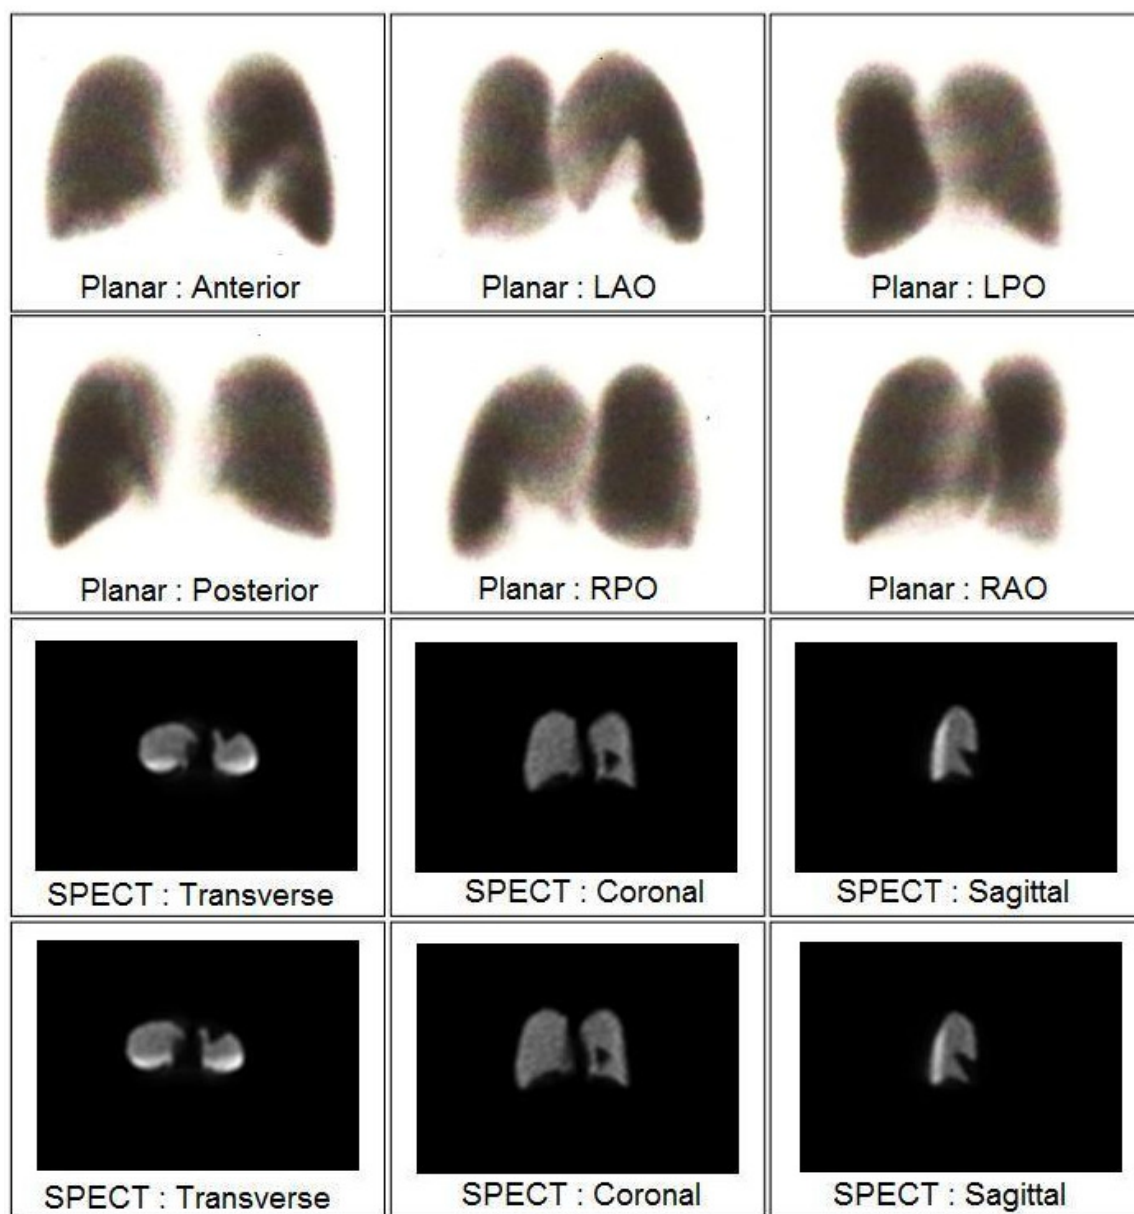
Planar and SPECT images of a perfusion defect within the medial and anterior basal segment of the left lower lobe.
